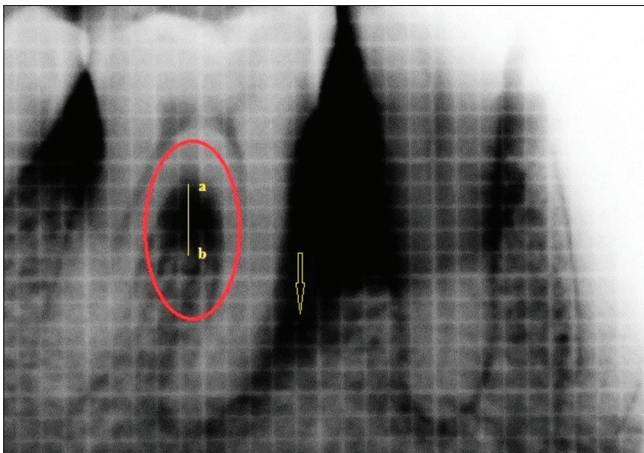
Preoperative radiograph showing furcation defect having ~ 3 mm vertical dimension (a and b) (Also, arrow showing large intrabony defect on the mesial of right mandibular first molar)
